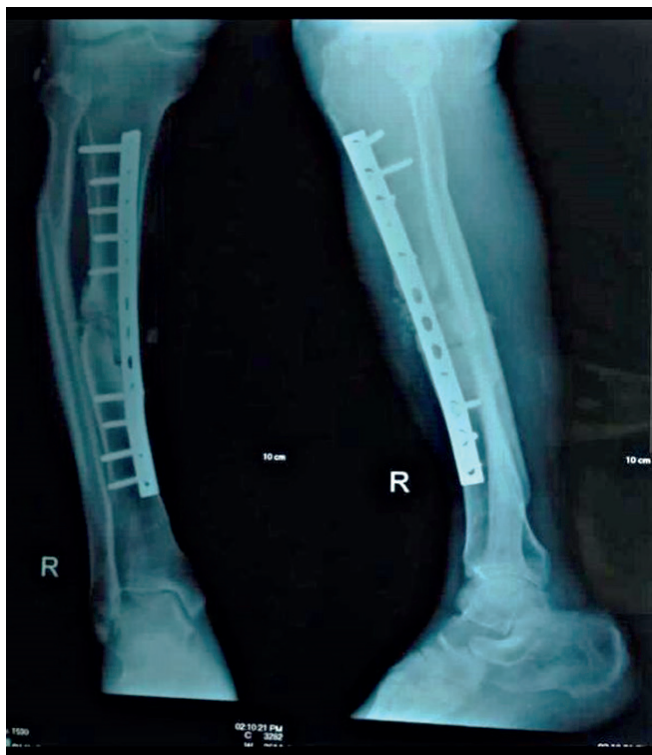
The AP (Anteroposterior) and Lateral X-ray Views of the Right Cruris Post-ORIF. This image demonstrates the alignment and stabilization achieved through the Open Reduction and Internal Fixation procedure. (Courtesy of Basuki).
